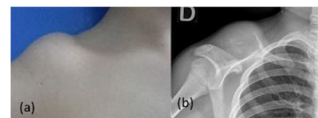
(a) Preoperative clinical photograph showing a large swelling in the right clavicular region. (b) radiograph showing a lesion involving the medial aspect of the right clavicle with marked expansion of the cortex
